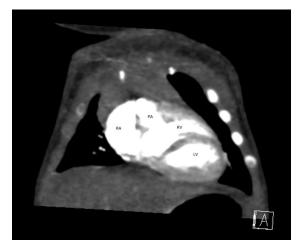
CT angiogram demonstrating upstairs- downstairs arrangement of Right Ventricle & Left Ventricle.
